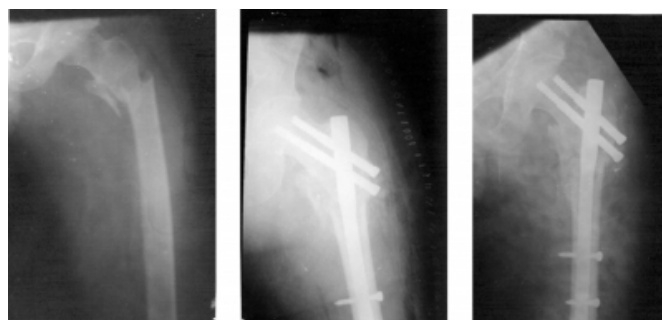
(a) Preoperative x-rays of a patient having unstable intertrochanteric fracture.
